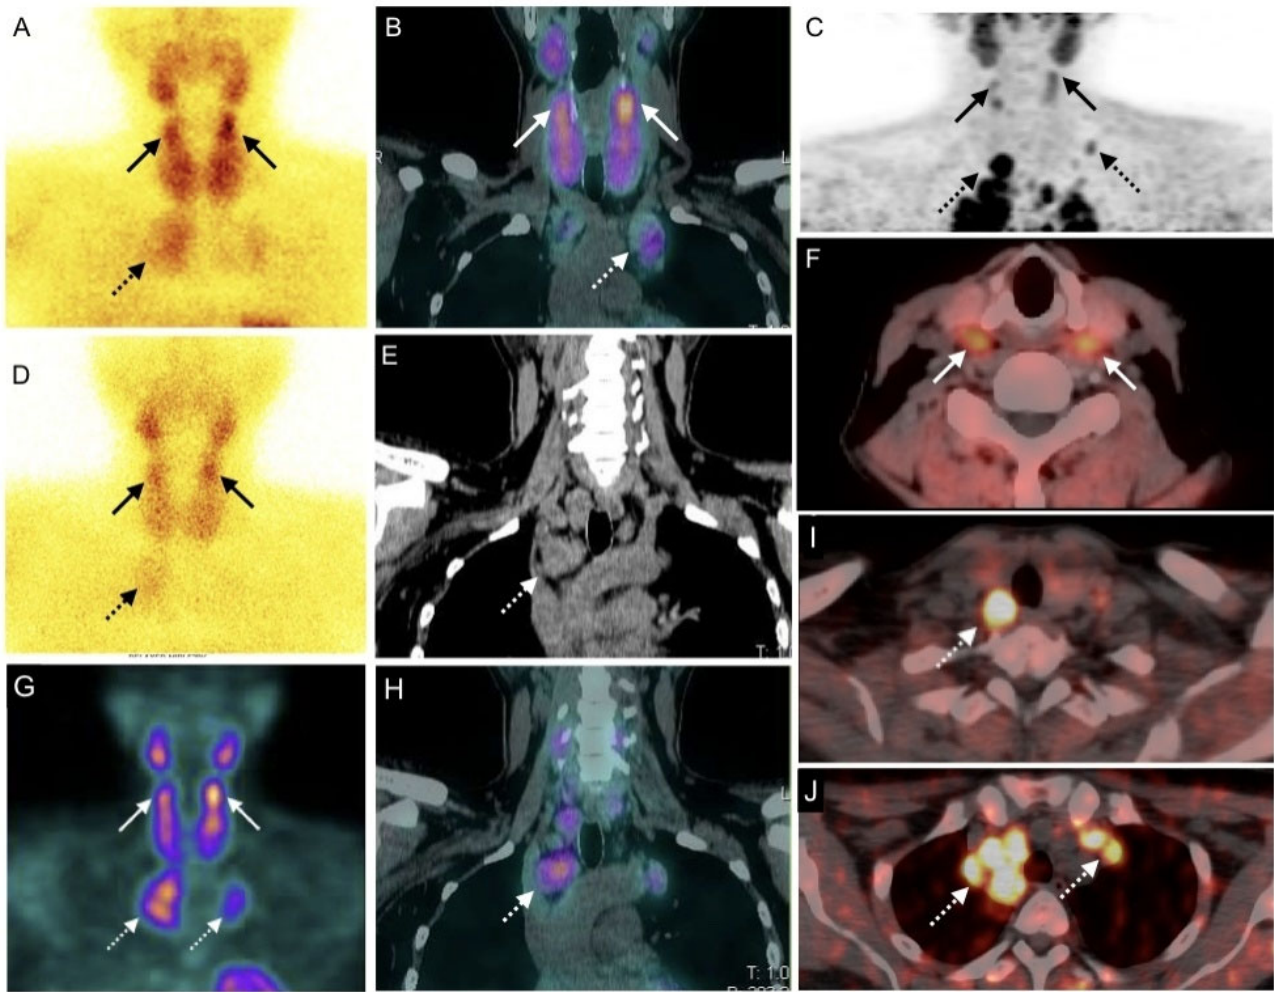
^{99m}Tc -sestamibi planar study done for hyperparathyroidism showing increased tracer avid foci with tracer retention near the upper poles of both lobes of thyroid glands in early static and delayed images (A, D; solid arrows). Early SPECT MIP and coronal fused images localizing the increased tracer in two hypodense lesions in postero-superior location of the both lobes of thyroid gland (B, G; solid arrows). Tracer avid enlarged mediastinal and cervical lymph nodes were also seen (A, B, D, E, G, H; broken arrows). Regional neck ^{18}F -fluorocholine PET/CT showing tracer avid lesions located near the upper poles of thyroid lobes suggestive of bilateral superior parathyroid adenomas on PET MIP and transaxial fused images (C, F; solid arrows) along with intense tracer avid enlarged mediastinal and cervical lymph nodes (I, J; broken arrows).
